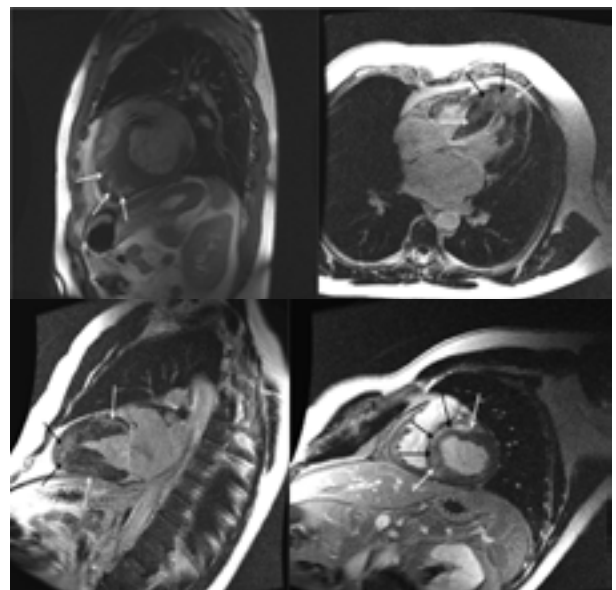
Scar areas in the MRI images (Locations indicated by arrows).
